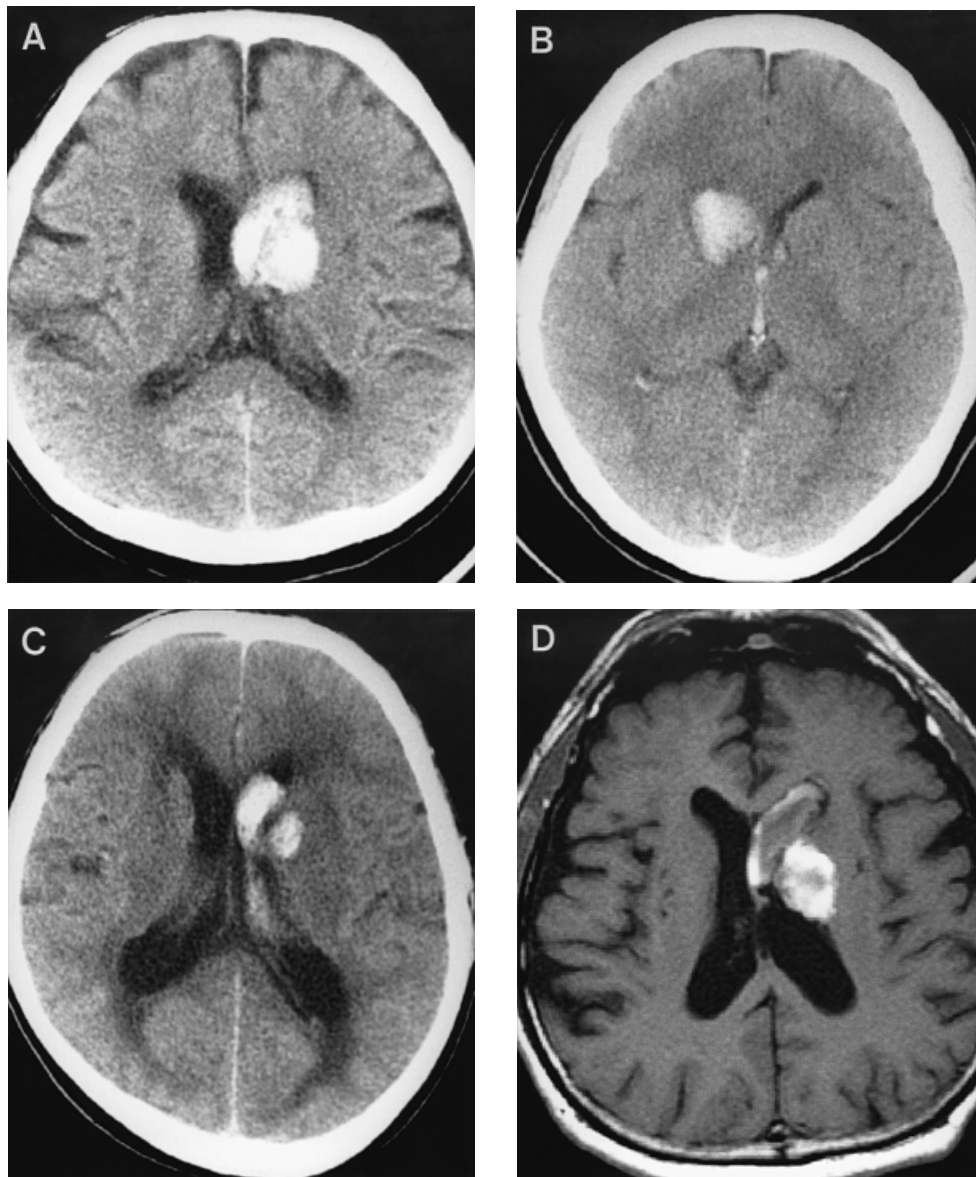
CT (A–C) and T₁-weighted MR (D) images showing the anterior type of SCHs. Haematomas may be located in the head (A and B) or in the body of the caudate nucleus (C and D). They usually rupture into the lateral ventricle. Each picture is from a different patient.
